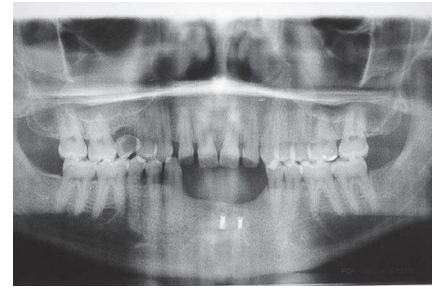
Panoramic radiograph of jaws after distraction.
